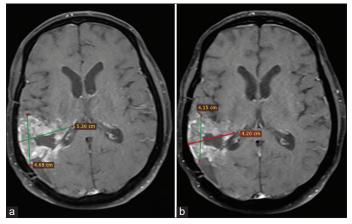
(a) Pre-treatment axial post-contrast T1-weighted image showing heterogeneously enhancing tumor volume 58.42 cc; (b) Post-treatment (day 20) axial post-contrast T1-weighted image showing reduction in the tumor size volume 36.07 cc
